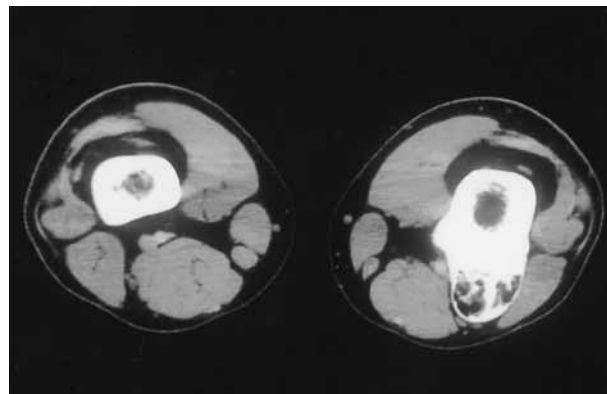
Axial CT scan through the lesion
